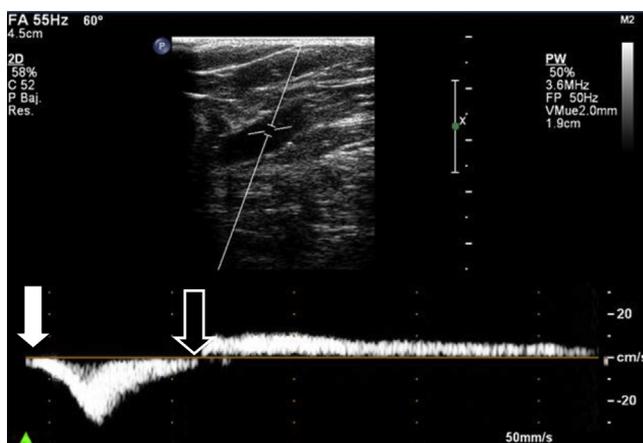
Ultrasound scanning for superficial venous insufficiency. Venous valve reflux at the saphenofemoral junction after calf compression (solid white arrow) and release of compression (white arrow outline).
